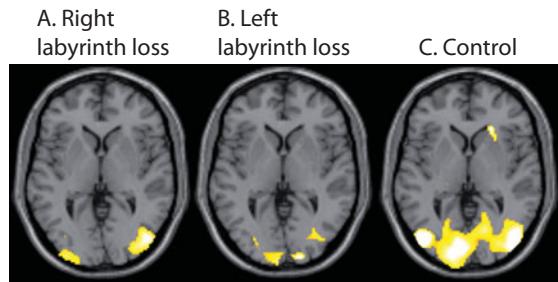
Patients with unilateral vestibular loss learn to suppress visual motion. Functional magnetic resonance images from patients with failure of the right (A) or left (B) vestibular apparatus and from controls (C) were obtained during optokinetic nystagmus, a physiological form of nystagmus that can be elicited by a repeating visual pattern (see text). The scans are horizontal sections with the occipital cortex at the bottom. Patients showed less activation of visual areas of cortex than did control patients. This was interpreted as evidence that the patients were effectively suppressing visual motion stimulation and thus had smaller responses to the oscillopsia accompanying optokinetic nystagmus. Reprinted from Deutschlander A., et al. Unilateral vestibular failure suppresses cortical visual motion processing. *Brain* 131: 1025-34, 2008, with permission of the publisher, Oxford University Press.
